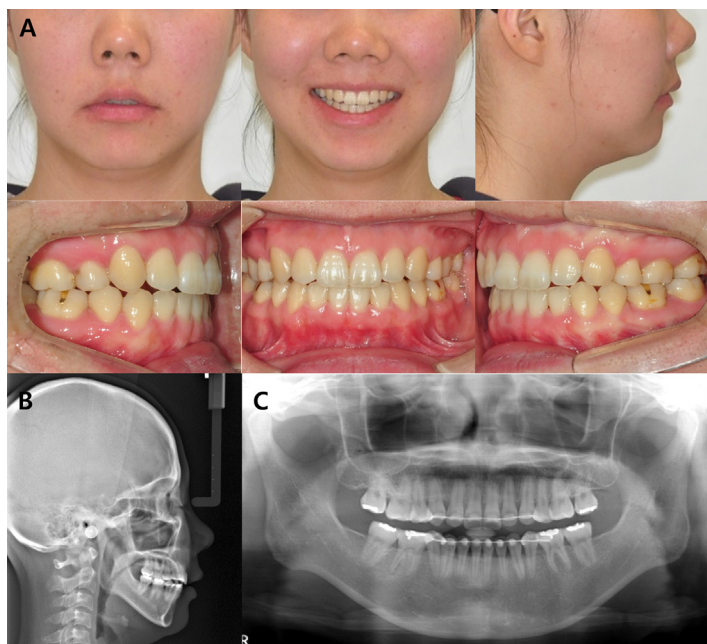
Case 3. Posttreatment data. A: Facial and intraoral photographs, B: Lateral cephalogram, C: Panoramic radiograph.
